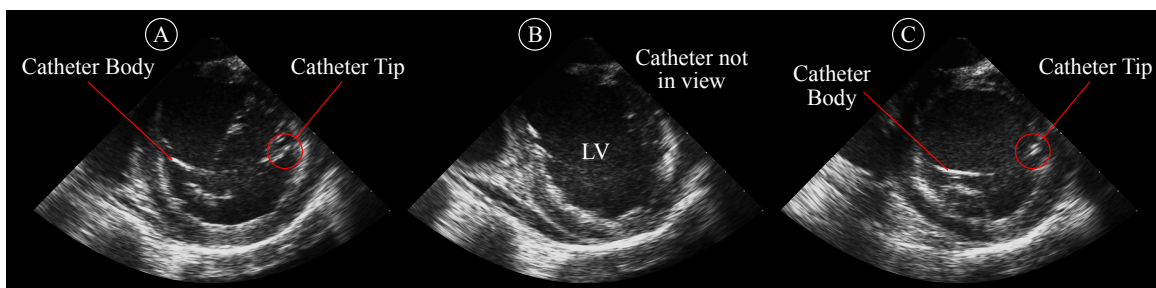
Automatically pointing the ultrasound imager at a manually-steered target catheter in vivo.* (A) Robot points ultrasound imager at target. (B) Clinician moves target out of view. (C) Robot reorients ultrasound imager to continue pointing at target.
